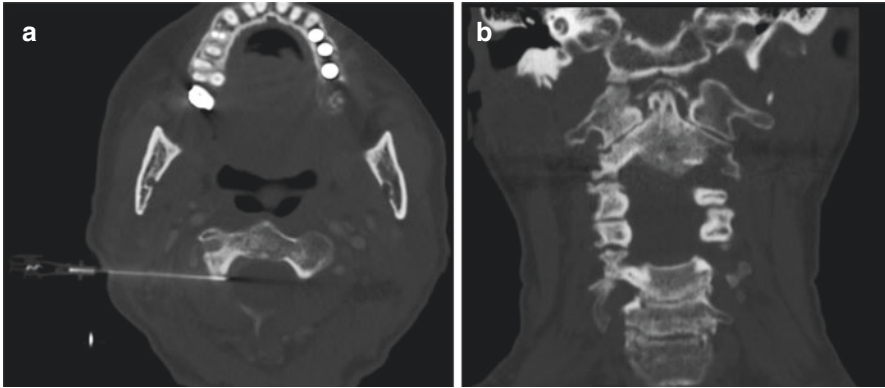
Axial CT image (a) showing appropriate placement of a radiofrequency cannula for thermal ablation of the right C2 dorsal root ganglia for cervicogenic headache. Coronal CT reformation (b) shows severe asymmetric osteoarthritis of the right C1–C2 articulation
